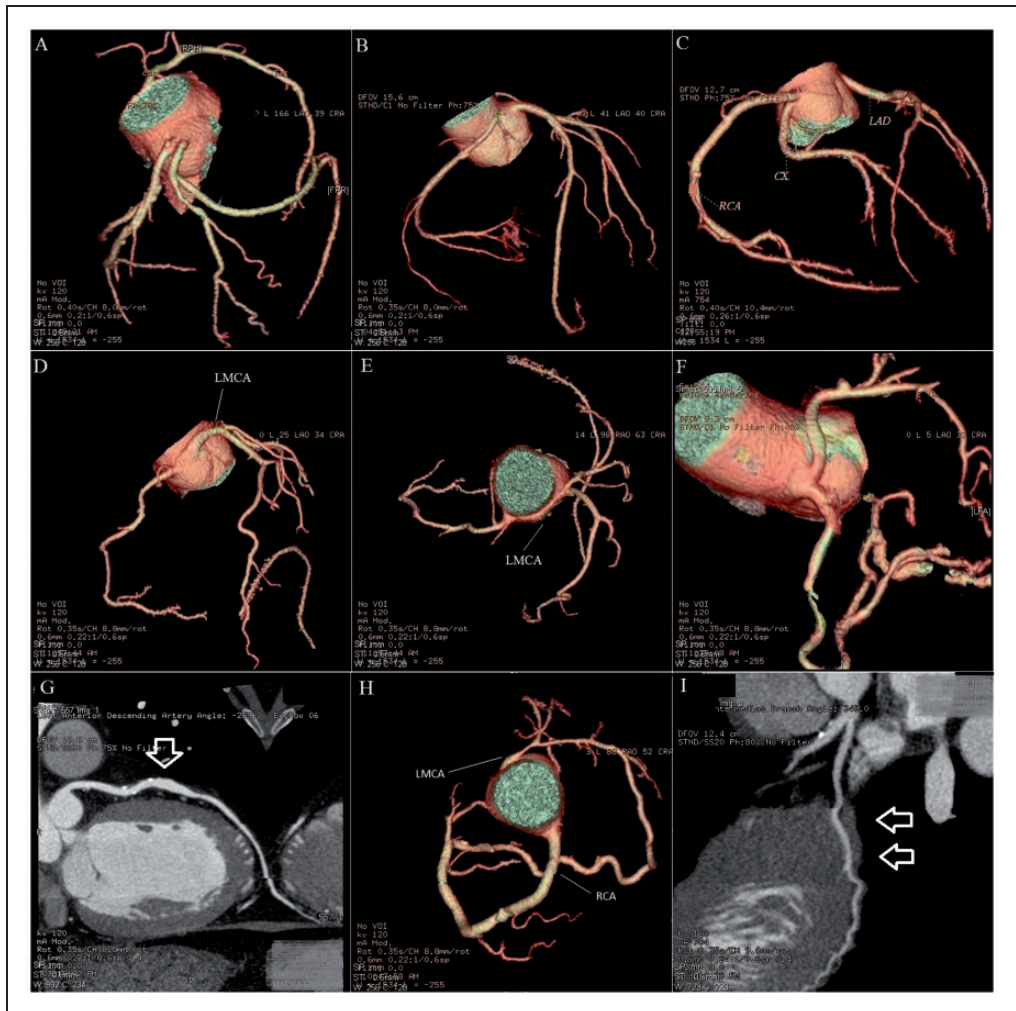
(A) Split origination of the LMCA. Multi-slice computed tomography coronary angiography (MSCT-CA) image shows the absence of the LMCA and the separate origins of the LAD and CX. (B) RCA arising from the left anterior sinus of Valsalva. (C) Anomalous origin of the CX from the right anterior sinus of Valsalva. (D,E) LMCA arising from the right anterior sinus of Valsalva. Image shows the opening of the LMCA and its interarterial course between the ascending aorta and the pulmonary artery. (F) A volume rendering image of MSCT-CA shows a single coronary artery originating from the right sinus of Valsalva. This was classified as the type RI pattern, with passage of the LMCA between the pulmonary artery and aorta. (G) Image shows coronary ectasia of the proximal segment of the LAD, which is indicated with a white arrow. (H) Volume rendering image of the coronary arteries shows no atherosclerotic lesion, but hypoplasia of the LMCA with compensatory enlargement of the RCA. (I) Intramural coronary artery (muscular bridge). MSCT-CA image shows an example of proximal and mid segments of the LAD with myocardial bridging, which is indicated with white arrows.
